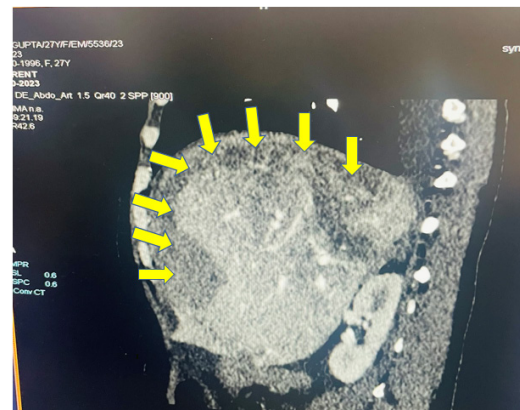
Saggital section on CT showing ruptured hepatic adenoma.
